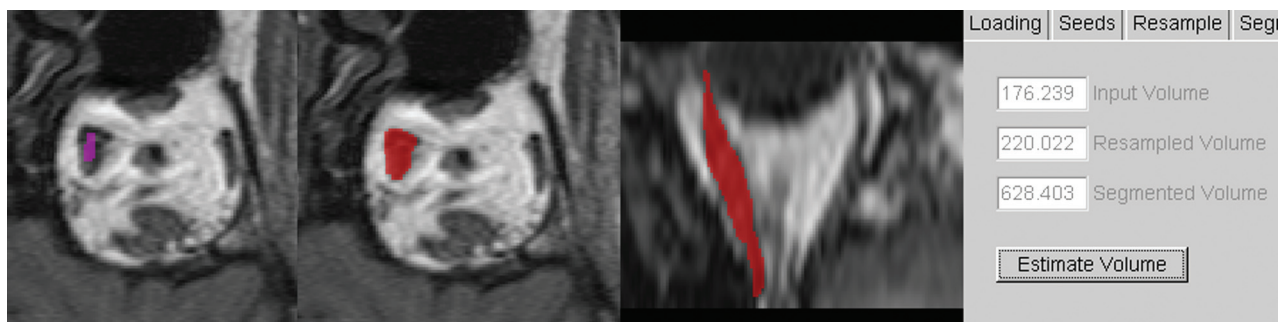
The muscle volumes calculated by the NSI application; indication of area of interest in the muscle interior, fitting the area inside the contour to the chosen element of the MR image and determination of the last value
